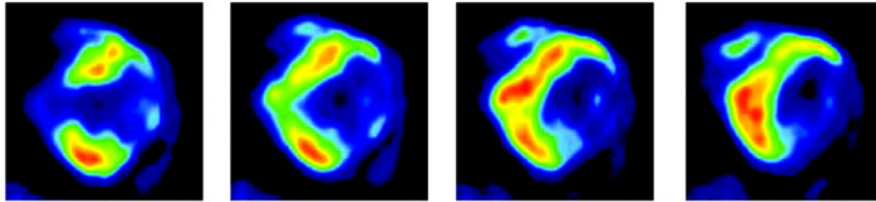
CT images of the heart. Figure from [Bruzzi et al., 2006].
